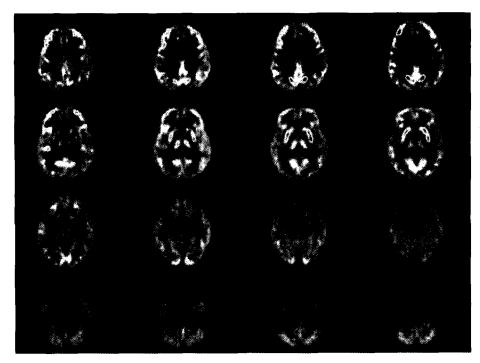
Seventy-one years old male with Parkinson's disease. Axial image of F-18 FDG shows mild cortical hypometabolism. There is no significant hypometabolism in the striatum.
